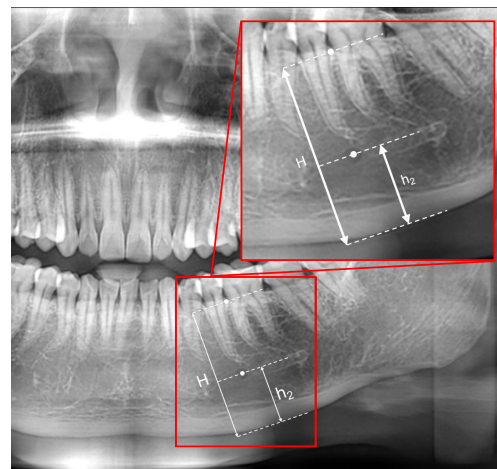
The definition of *MRI*
